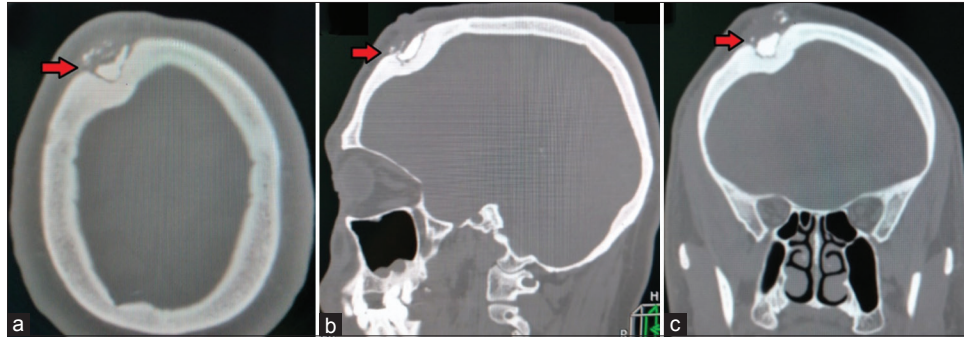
Pre-operative brain CT in the bone window; (a) axial slide, (b) sagittal, and (c) coronal. The arrow points to the location of the foreign body nested in a bone defect
